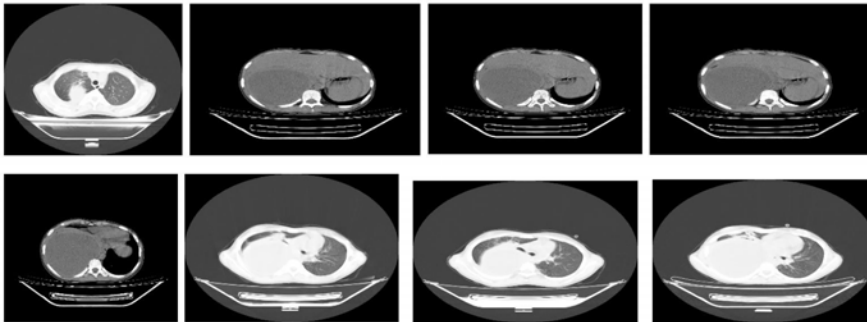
Contrast Enhanced Computed Tomography (CECT) scan of the thorax Well defined cystic lesion in right lower lobe causing collapse of right upper & middle lobes with mediastinal shift.
